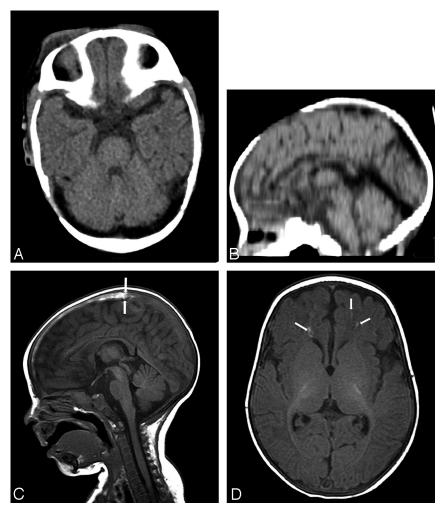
A*, Axial noncontrast CT image shows decreased attenuation of the transverse sinuses. The density of the transverse sinuses is -15 HU. *B*, Reformatted midsagittal CT image demonstrates hypoattenuation in the superior sagittal sinus, internal cerebral veins, vein of Galen, straight sinus, and torcula. *C*, Sagittal T1-weighted (TR/TE, 500/12 ms; NEX, 4) image shows lack of normal signal void in the superior sagittal sinus is hyperintense, and a fluid-fluid level (*arrows*) is present near the vertex. *D*, Axial T1-weighted (TR/TE, 500/12 ms; NEX, 4) image displays linear T1 shortening (*arrows*) in the anterior frontal white matter, corresponding to fat in the deep medullary veins.
